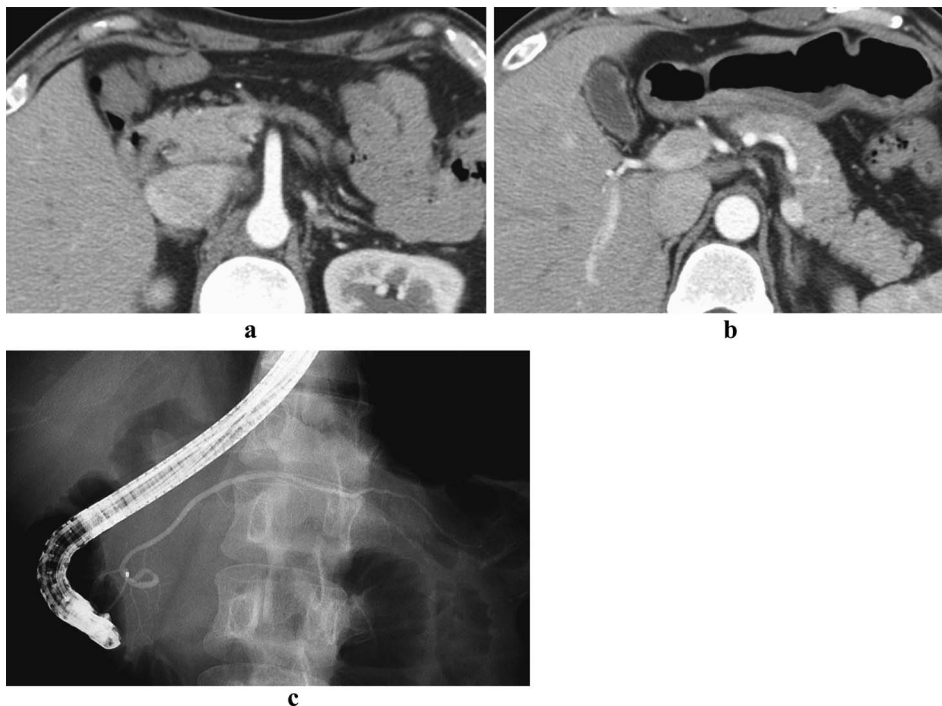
No definite abnormalities are shown in the pancreas on enhanced computed tomography (a, b) or endoscopic retrograde cholangiopancreatography (c).
